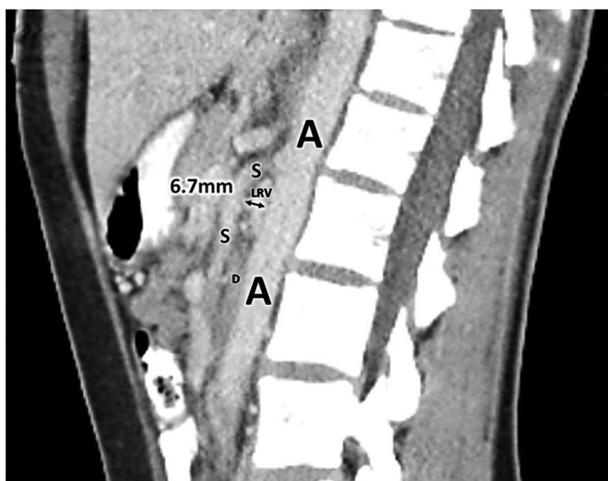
Computed tomography results confirming superior mesenteric artery syndrome. A = Aorta, S = Superior Mesenteric Artery, LRV = left renal vein, D = duodenum. The Aortic/SMA distance \leftrightarrow was measured at 6.7 mm.
